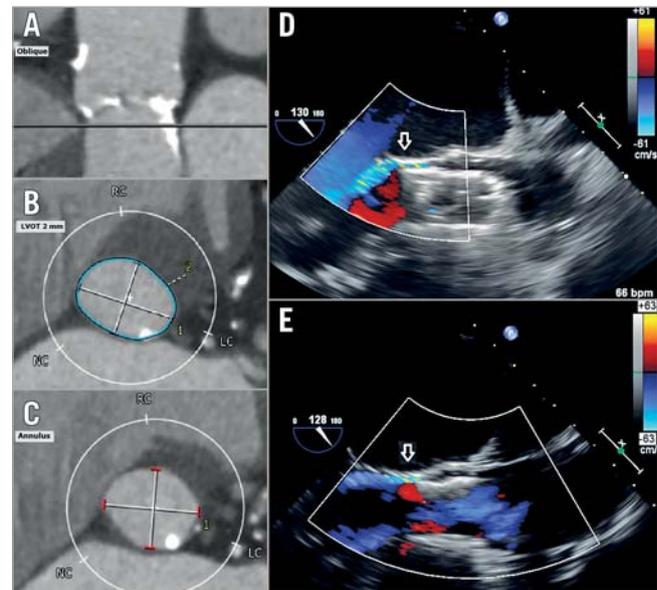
Case 2. Transoesophageal imaging pre and post balloon post-dilation of the LOTUS valve. MDCT imaging demonstrates calcification of the native aortic valve, particularly at the site of the left coronary cusp (A-C). Transoesophageal echocardiogram shows moderate paravalvular AR immediately after LOTUS valve implantation, along the area of calcification, seen on long-axis view (D). The LOTUS valve was post-dilated with an 18×40 mm NuCLEUS-X™ balloon (B. Braun Interventional Systems, Bethlehem, PA, USA) with improvement in paravalvular AR to mild (E). Arrows indicate the paravalvular leak.
